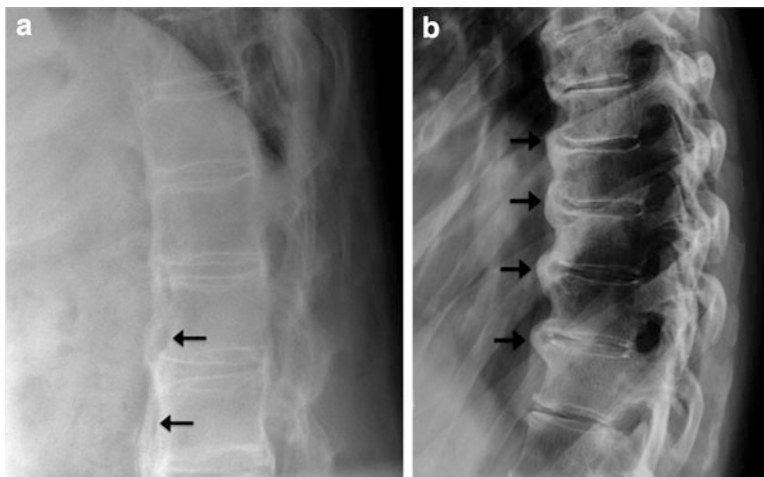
(a) X-ray showing diffuse idiopathic skeletal hyperostosis (DISH). This lateral radiograph of the thoracic spine demonstrates flowing ossification along the anterior longitudinal ligament with radiolucency between the vertebral body and anterior longitudinal ligament (arrow). (b) X-ray showing diffuse idiopathic skeletal
